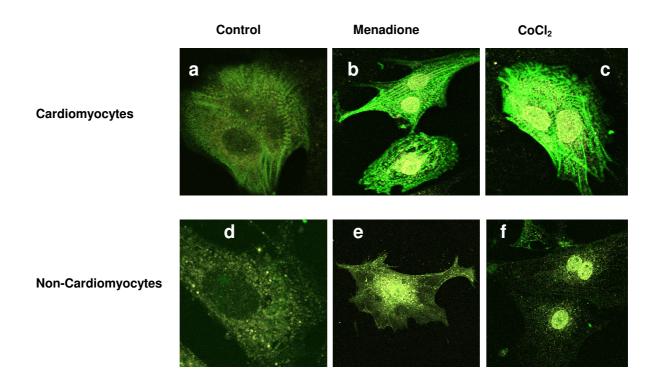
Induction of nuclear translocation of CT-1 in cardiomyocytes (b, c) as well as non-cardiomyoctes (e, f) after treatment with 20  $\mu$ M Menadione (b, e) and 50  $\mu$ M CoCl<sub>2</sub> (c, f).
